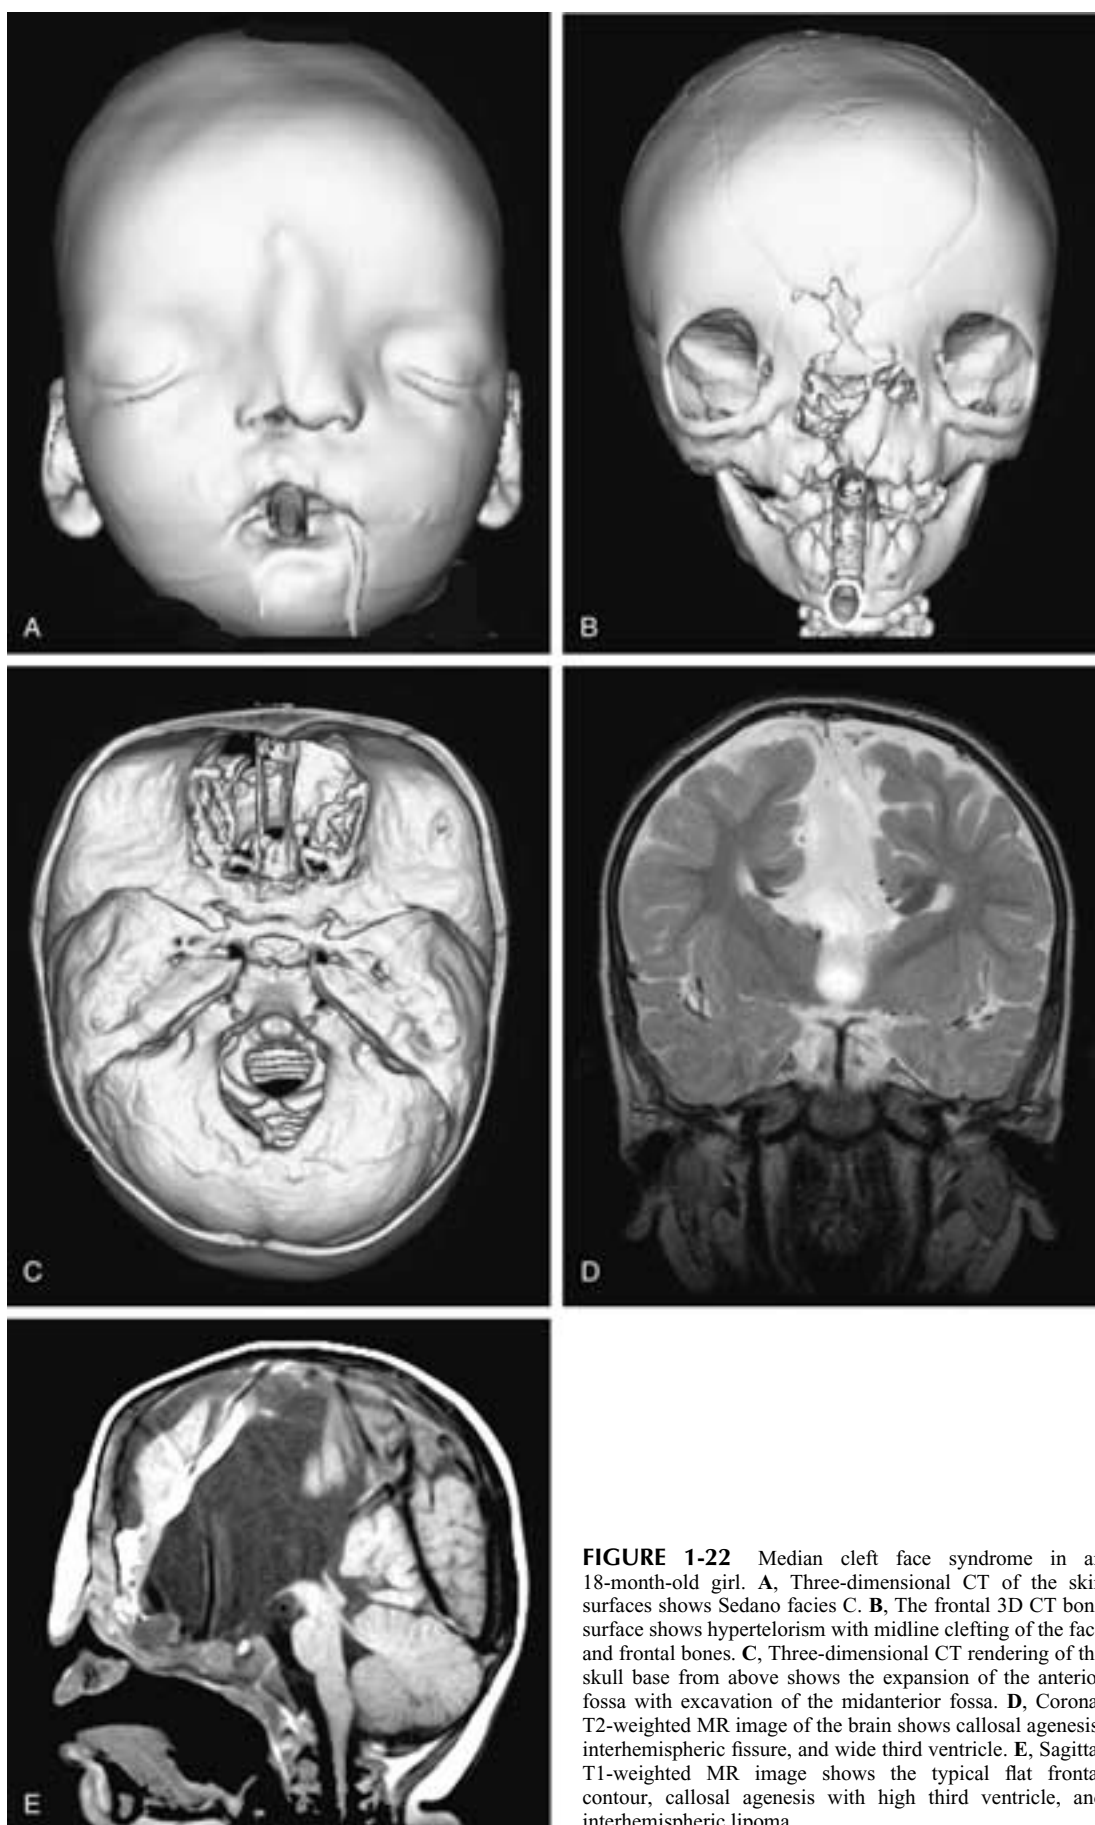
Median cleft face syndrome in an 18-month-old girl. A, Three-dimensional CT of the skin surfaces shows Sedano facies. B, The frontal 3D CT bone surface shows hypertelorism with midline clefting of the face and frontal bones. C, Three-dimensional CT rendering of the skull base from above shows the expansion of the anterior fossa with excavation of the midanterior fossa. D, Coronal T2-weighted MR image of the brain shows callosal agenesis, interhemispheric fissure, and wide third ventricle. E, Sagittal T1-weighted MR image shows the typical flat frontal contour, callosal agenesis with high third ventricle, and interhemispheric lipoma.
